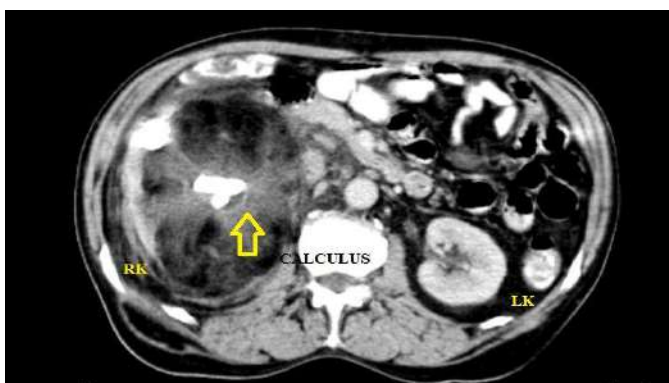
CT image showing right renal calculi and fat in right kidney
